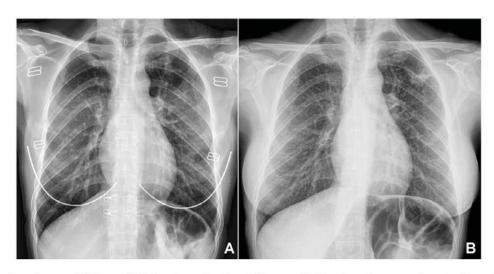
Chest radiography images (A) before and (B) after nine months of isoniazid treatment for the patient who progressed to active disease following the latent tuberculosis infection treatment.
